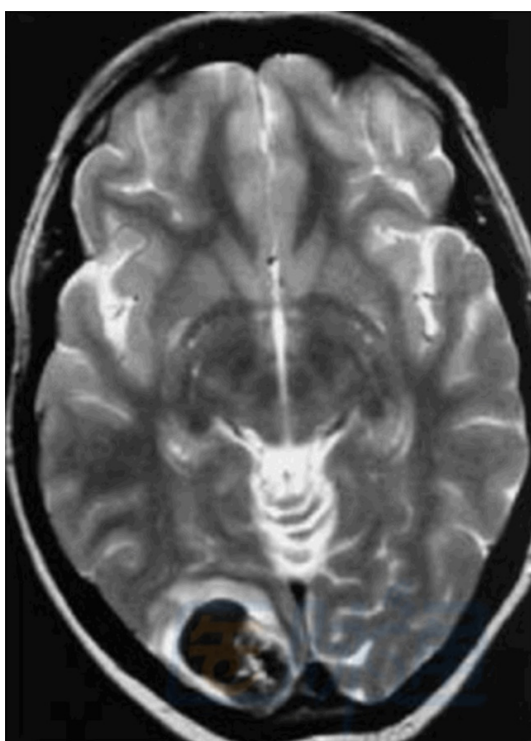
T2WI performance in MRI.
